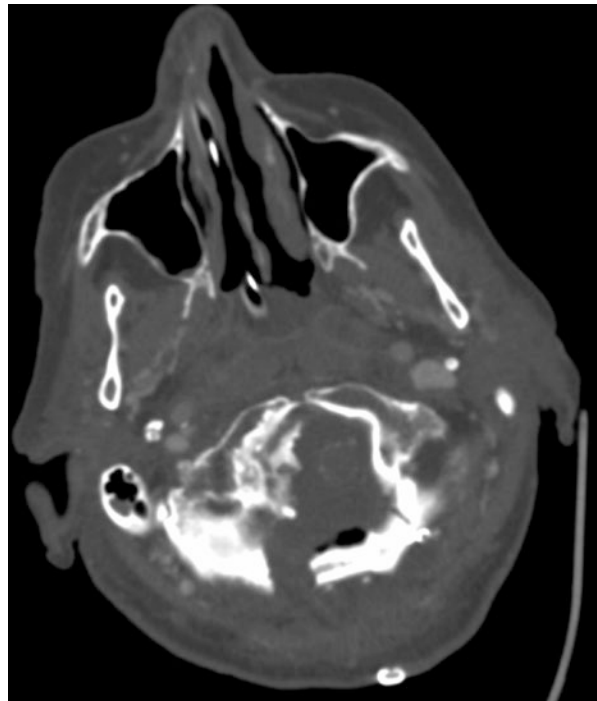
Post-operative axial CT bone scan of the same patient as in Fig. 27.4. A hyperostotic shell is remaining along the dura and around the vertebral artery following subtotal removal of the calcified meningioma, which could be removed with extensive drilling with only. Decompression of the brainstem has been achieved
